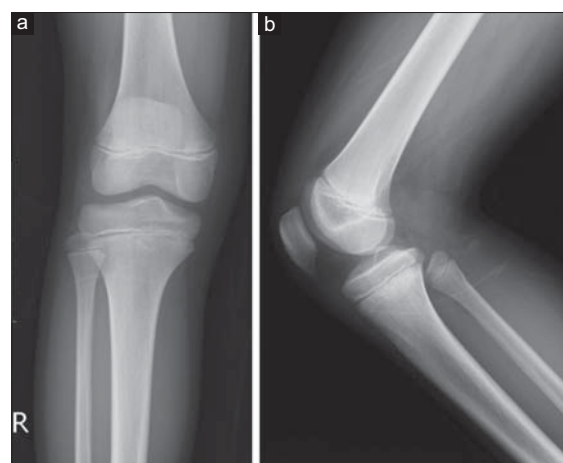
(a) Anteroposterior and (b) lateral radiographs of the same knee obtained 4 years after diagnosis shows resolution of the osteochondroma
